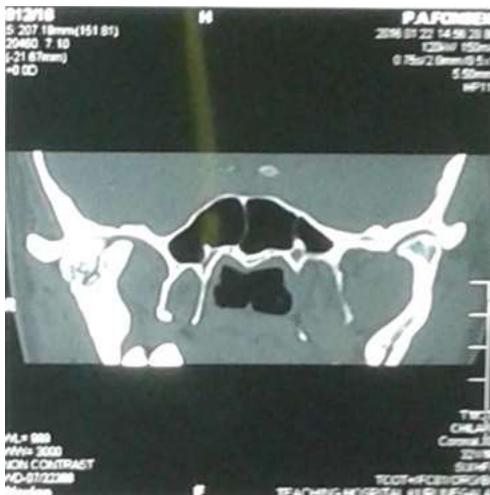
CT Showing the TMJ region
